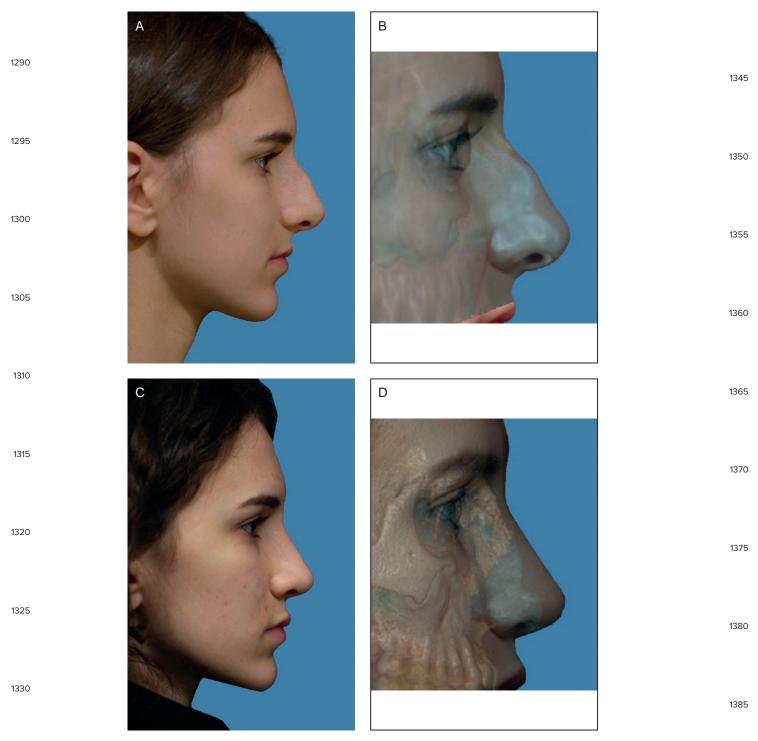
A 22-year-old female. Photographs of nasal bones pretreatment (A) and 1 year posttreatment (C) and 3-dimensional CT lateral views pretreatment (B) and 1 year posttreatment (D). CT scan demonstrates a flat bony cap postoperatively following an extensive modification of a wide and rigid bony cap. The mosaic method allows the surgeon to address one of the primary causes of recurrent hump deformities following dorsal preservation procedures—persistent curvature of the bony cap. CT, computed tomography.
